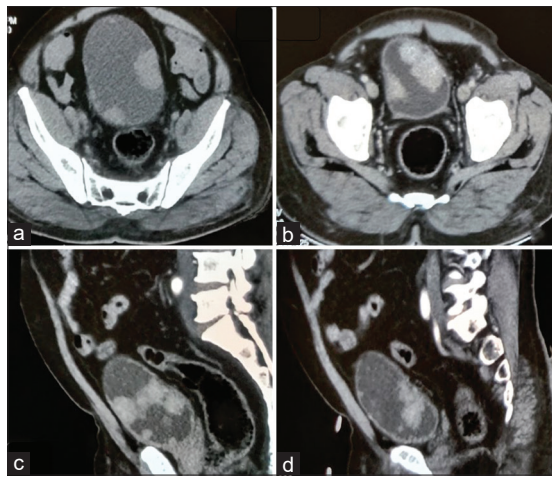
Computed tomography (a and b: Axial cuts; c and d: Sagittal cuts) of a patient presenting with gross hematuria showing multiple tumours over the anterior, posterior and lateral walls of the urinary bladder
